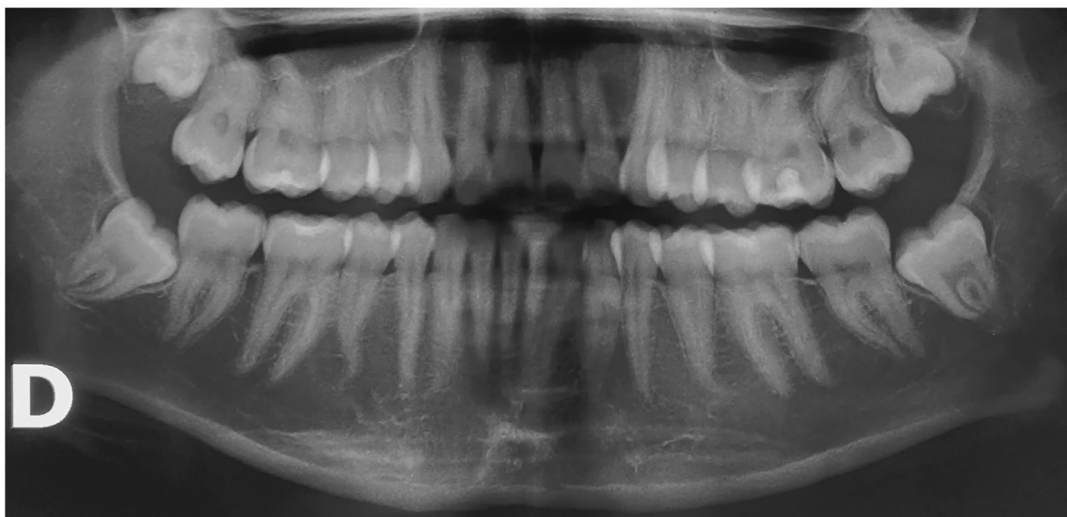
Orthopantomographic image showing bilaterally symmetrical lower third molars.
